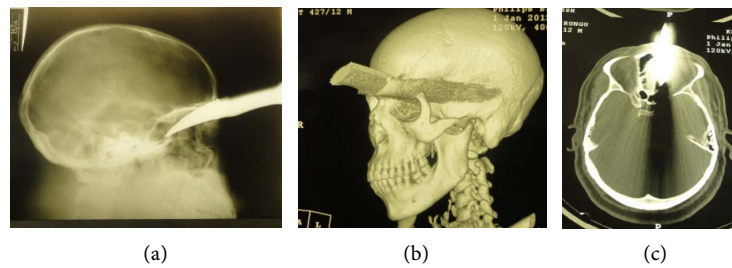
Lateral skull view (a) and CT scan, 3-D view (b) of an IPV patient with a knife stack on the forehead. Axial view (c) demonstrates streak artifact and beam hardening effect caused by the metallic knife.
